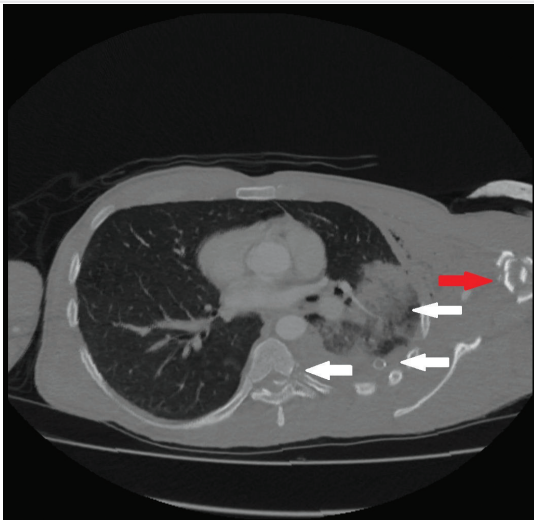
Axial computed tomography scan demonstrates fracture of the left humerus (red arrow), left hemopneumothorax, chest tube and possible trajectory of bullet in the upper lobe (white arrows)
